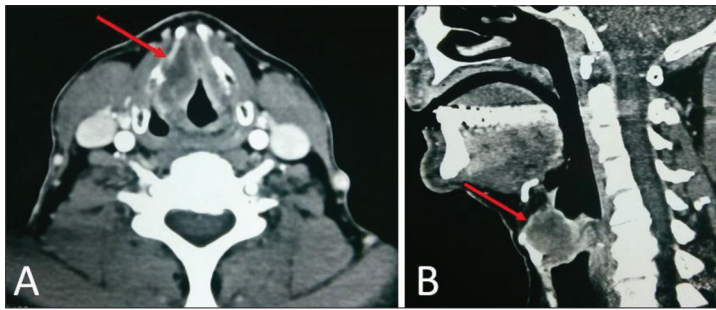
Computed tomography scan of the neck: axial (A) and sagittal view (B); arrows point to laryngeal leiomyosarcoma
